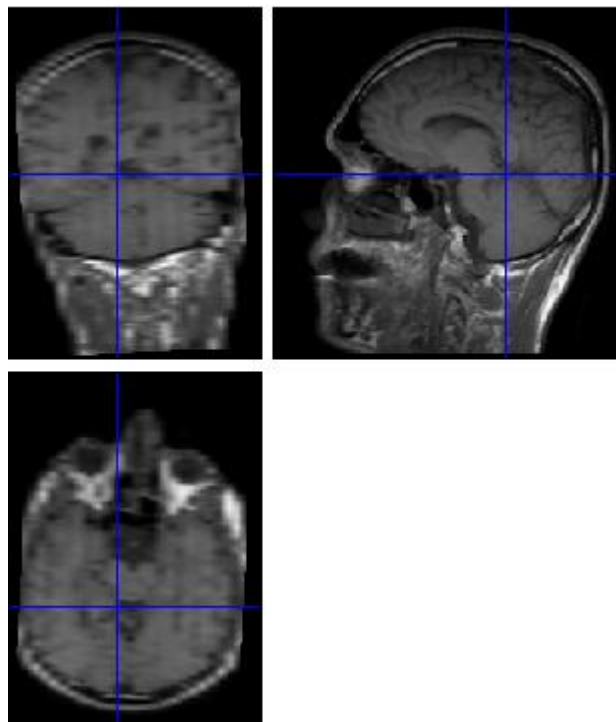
Sample T1 weighted sagittal MR image in Nifti format.
